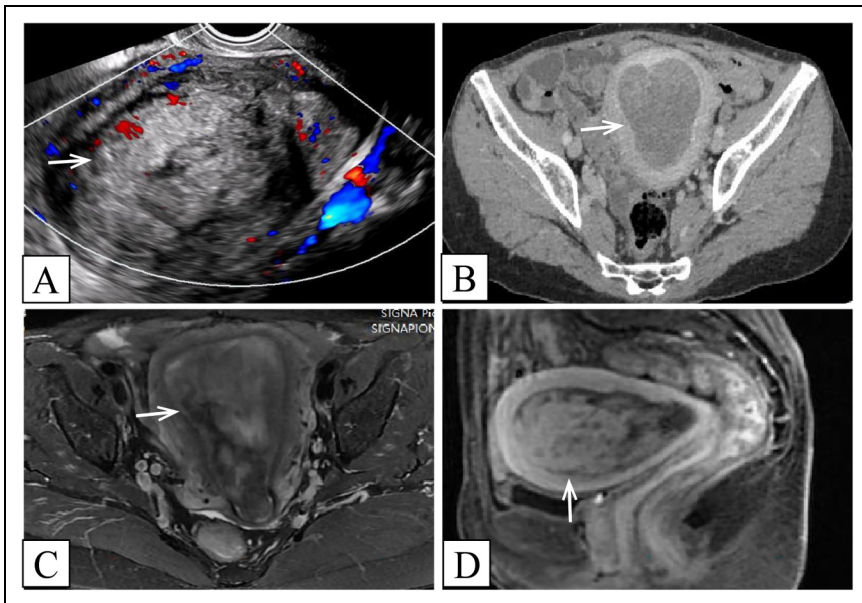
Imaging characteristics of this case. (A) Transvaginal ultrasound showed a mixed echogenic mass in the uterine cavity, and the endometrium was unclear. (B) CT enhanced scan showed mass shadows in the uterine cavity with progressive uneven enhancement, and uneven thickening of the endometrium. (C) MRI T2WI transverse view showed mixed slightly high signal and isointense mass shadow in the uterine cavity, with higher signal small cystic lesions in it, and uneven thickening of the endometrium. (D) MRI enhanced scan T1WI showed that the mass in the uterine cavity was obviously unevenly enhanced, and the degree of enhancement was similar to that of the myometrium. There were small cystic non-enhanced lesions in the mass. The thickened endometrium was slightly enhanced.
